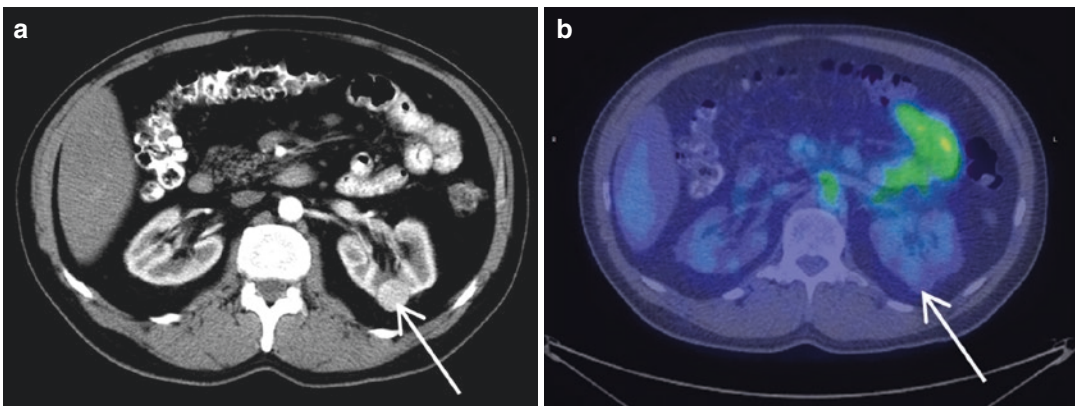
Bilateral clear cell renal carcinoma. 124I-cG250 PET/CT in a 65-year-old male with bilateral renal masses. (a) Triphasic CT shows a 5-cm enhancing lesion in the right kidney and a 2-cm enhancing lesion in the left
